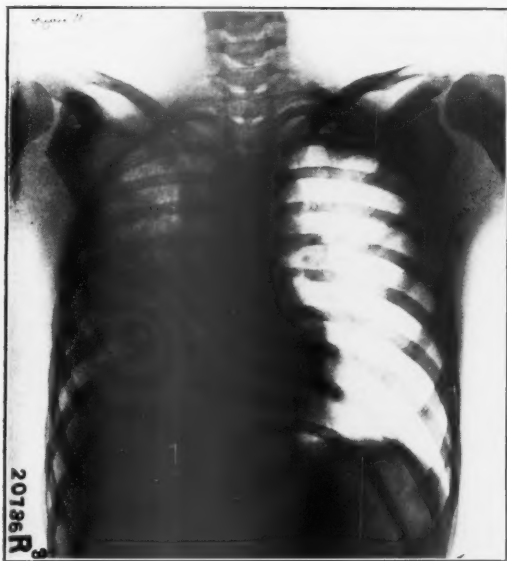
Roentgenogram of same patient as Fig. 1, immediately following bronchoscopic aspiration. Air is entering all lobes of the right lung. The heart has gone back towards its normal position. The density of the right lung is very markedly decreased. Expectoration of secretion began and atelectasis recurred to some extent but the cough mechanism had become effective and the lung cleared rapidly. The lung was clear at the end of ten days.
